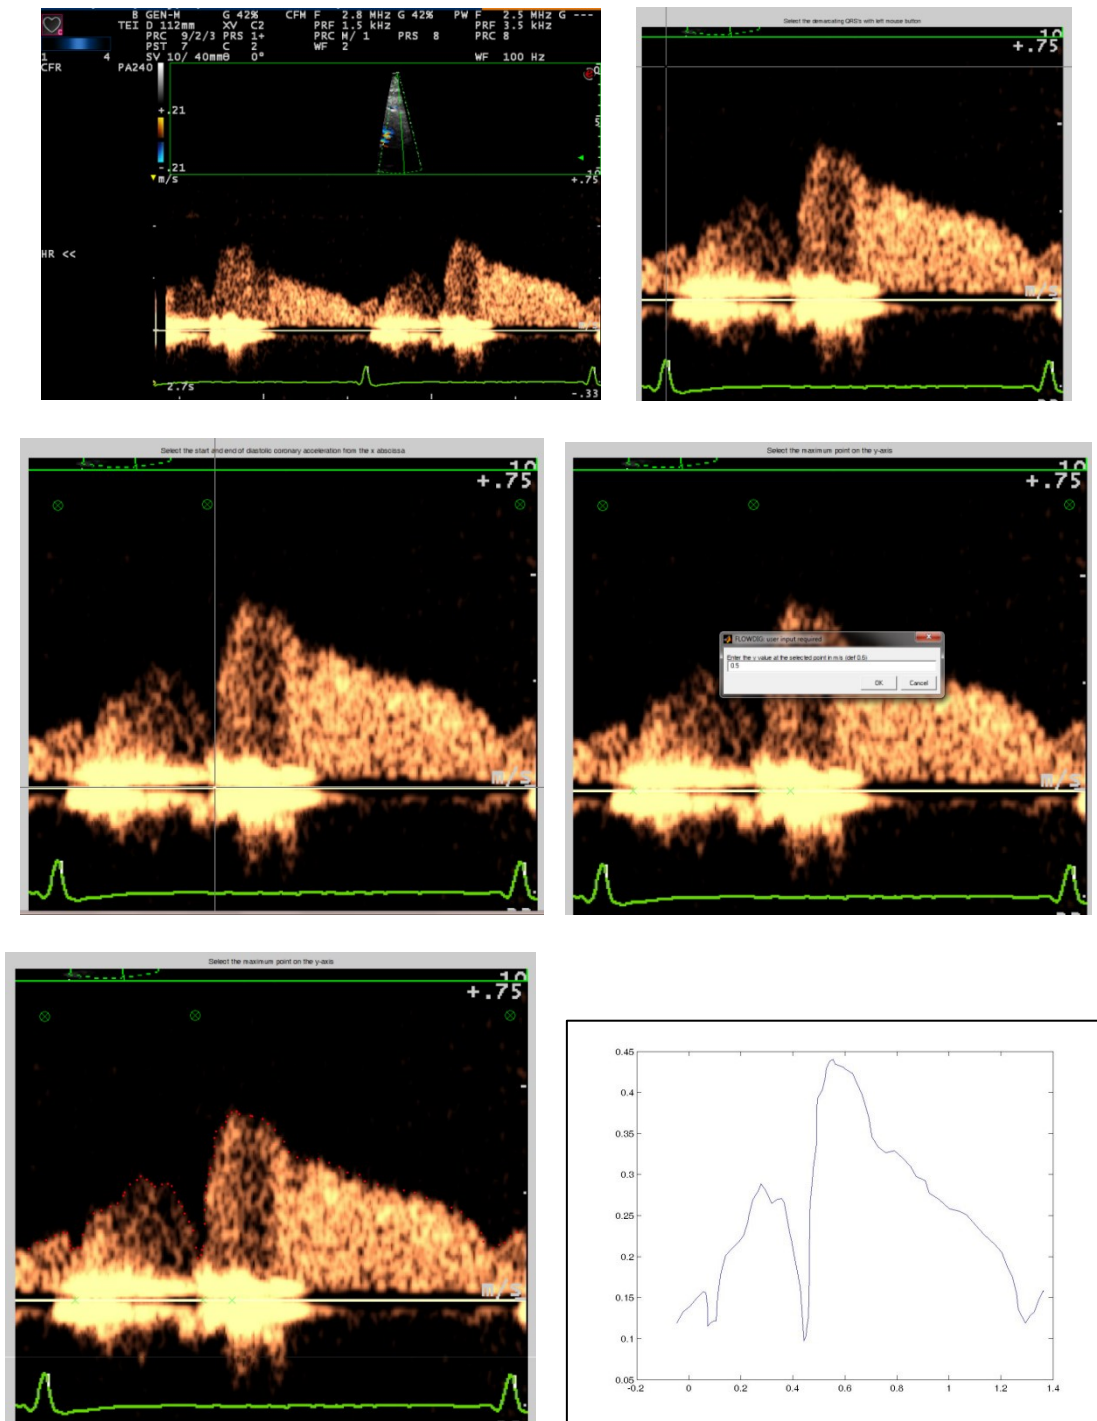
Post-processing of transthoracic echo-obtained coronary flow.
